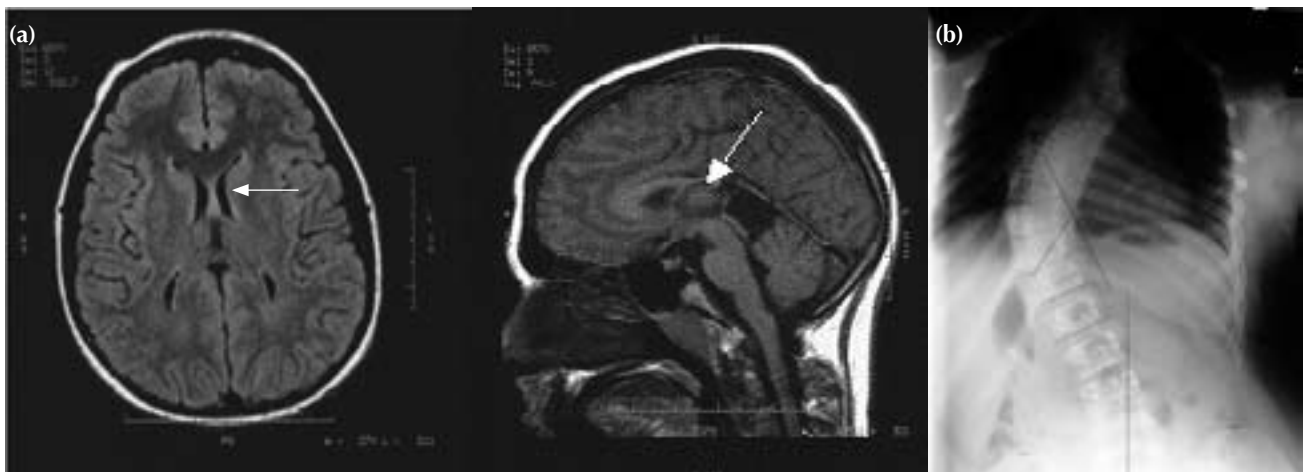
(a) Magnetic resonance images of the brain of a 12-year-old boy showing a pineal cyst (arrows). (b) Radiograph showing right thoracic scoliosis at the age of 16 years.
